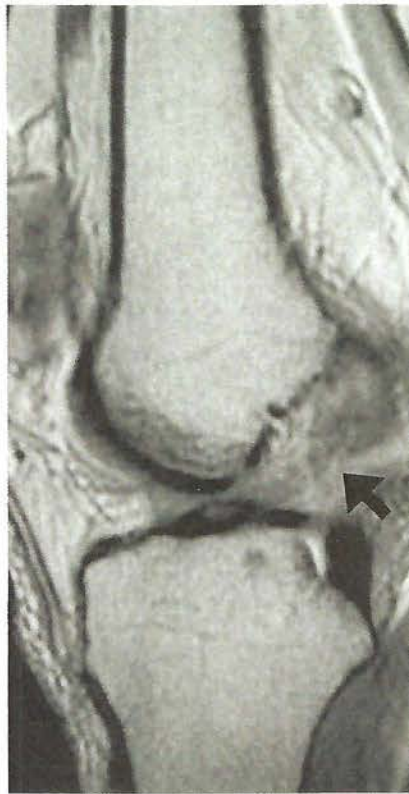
An acute tear of the ACL is evident on this T2-weighted magnetic resonance image of the knee.
